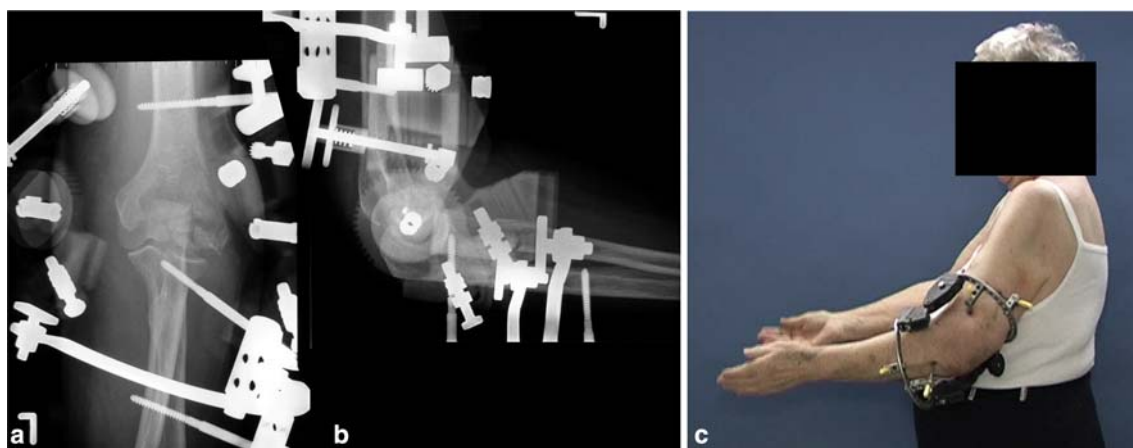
Anteroposterior (a) and lateral (b) radiograph made days after surgery show stable realignment of the fracture fragments and applied external device: Compass hinge (Smith and Nephew, Memphis, TE, USA). c Clinical impression of the hinge in place
